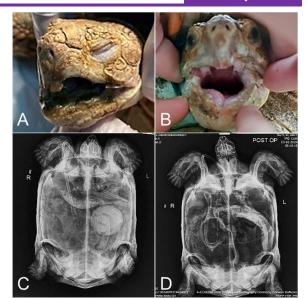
Imaging and Surgical Interventions in a Sulcata Tortoise. (A) Oral Fistula: A close-up image showing the oral fistula in the Sulcata tortoise. (B) Pre-operative X-ray: An X-ray image displaying a bladder stone in the urinary bladder. (C) Post-cleaning and Tube Insertion: A visual after cleaning the oral cavity and inserting a feeding tube through the esophagus. (D) Post-operative X-ray: An X-ray image taken after the surgical removal of the bladder stone, showing the cleared urinary bladder.
